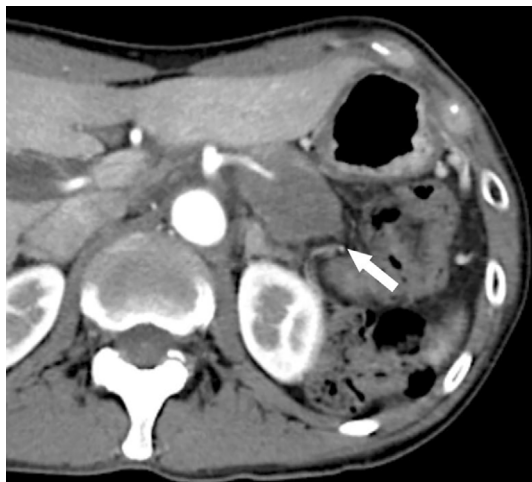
Contrast-enhanced computed tomography. Contrast-enhanced abdominal computed tomography showed a tumor in the tail of the pancreas. The tumor invaded the splenic artery and vein (arrow). Distal metastasis was not detected.
